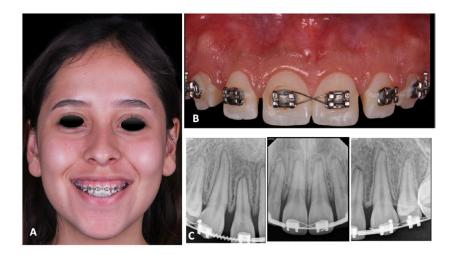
Initial photographs and radiographs. A. Facial photograph of a smile. B. Intraoral photograph with orthodontic appliances, where spaces between the teeth can be seen. C. Dentoalveolar radiographs that display the continuity of the lamina dura.
